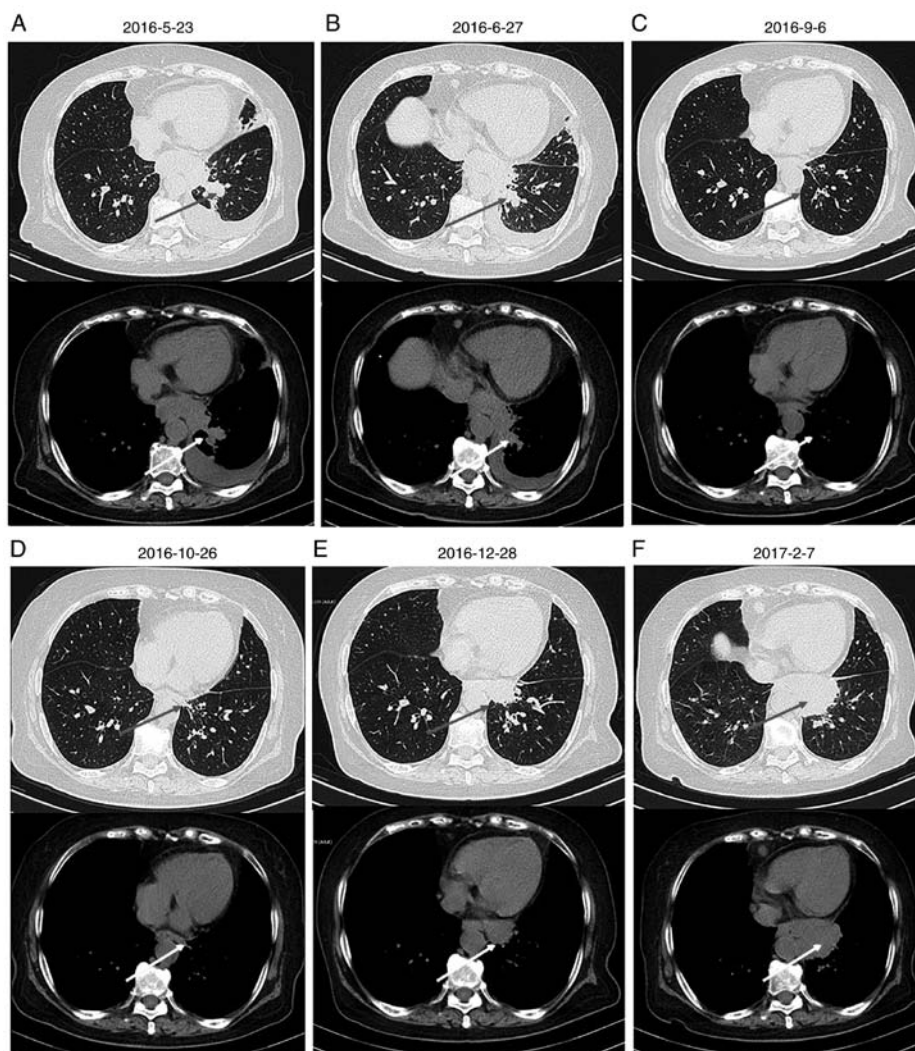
Chest computed tomography scan of the patient. Images were collected on (A) 2016-5-23, (B) 2016-6-27, (C) 2016-9-6, (D) 2016-10-16, (E) 2016-12-28 and (F) 2017-2-7. The arrows indicate the location of the tumor.
